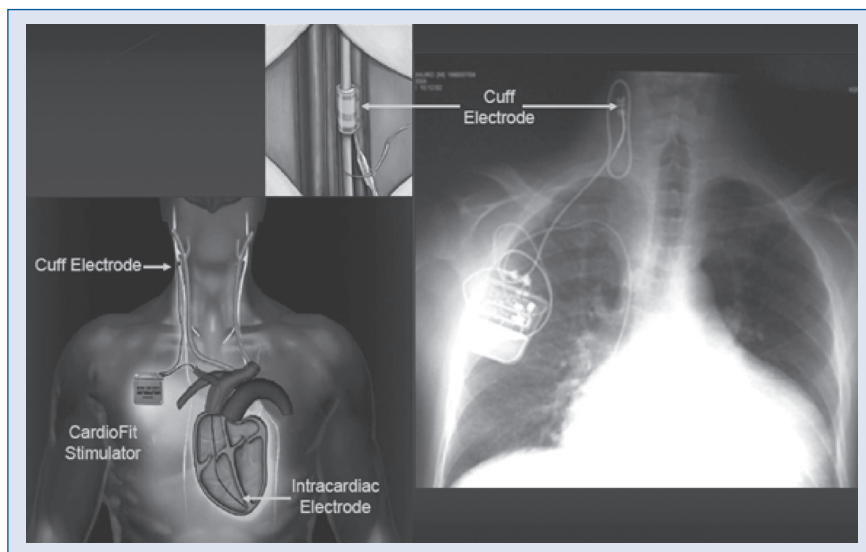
Design of the CardioFit vagus-nerve stimulation system. Upper left small panel: Cuff electrode placed around the right vagus nerve. Left lower panel: CardioFit pulse generator, cuff electrode at the right vagus nerve; right ventricular sensing lead at the right ventricular apex. Right lower panel: Chest X-ray of a patient with the CardioFit vagus nerve stimulation system in place. There is a wide loop of the lead from the vagus nerve insertion to the pulse generator in order to avoid stretching of the electrode with head or shoulder movement (design of the CardioFit vagus nerve stimulation system [BioControl, Yehud, Israel], reproduced with permission: Conf Proc IEEE Eng Med Biol Soc, 2009; 1: 2037.
